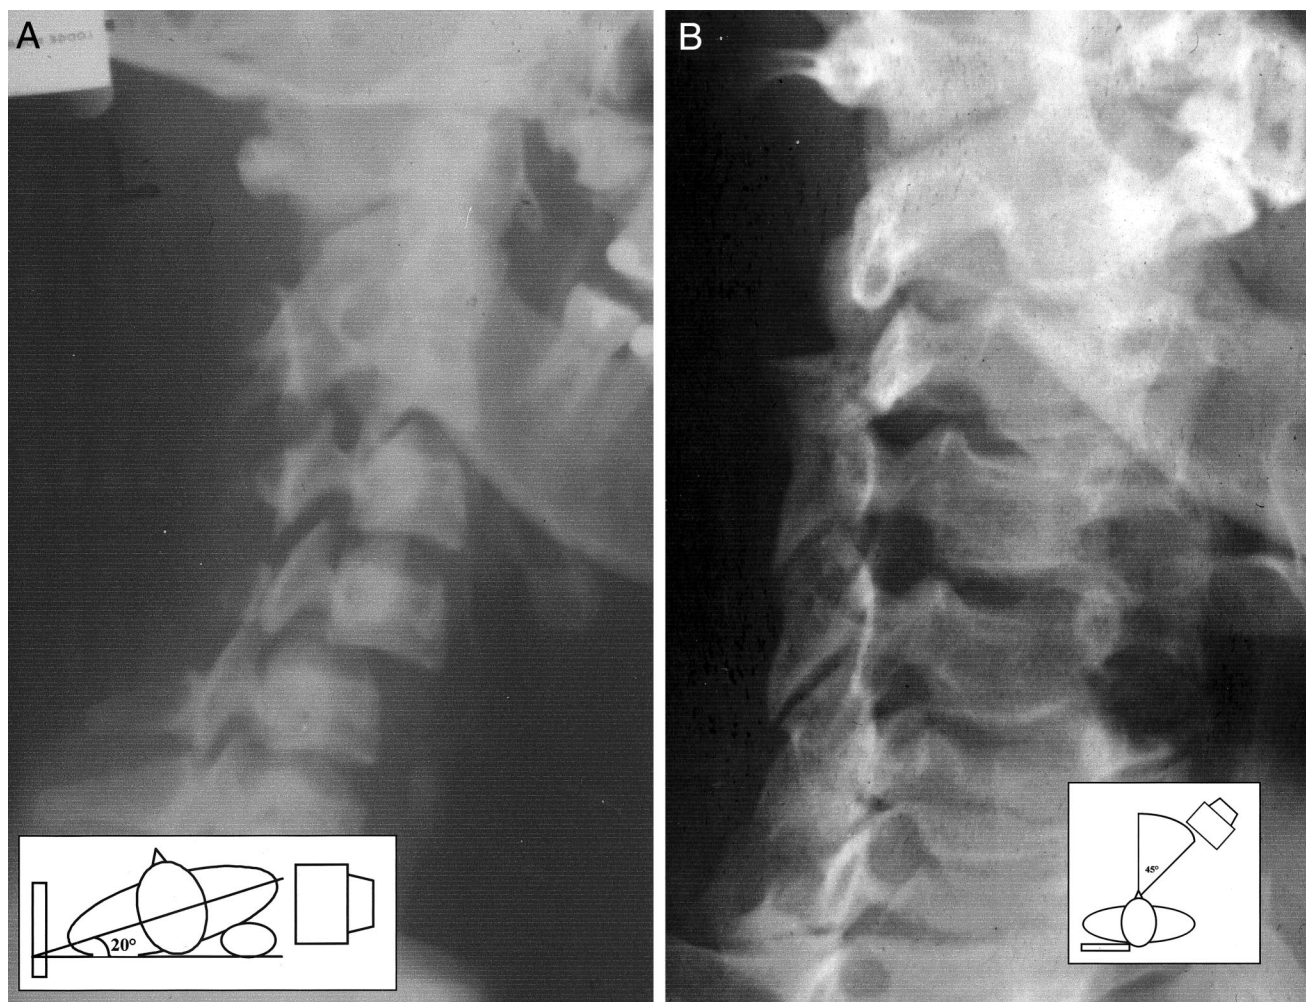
(A) Lodge Moor oblique view showing dislocation of C5/6 facet. These radiographs were obtained by inserting a pillow under one or the other shoulder. The facet seen in these radiographs correspond to the shoulder that is not elevated (see inset). (B) Oswestry oblique view showing dislocation of the C3/4 facet joint. These radiographs were obtained by sliding a radiograph cassette under the contralateral shoulder and neck while the x-ray beam was aimed at 45 degrees from the sagittal plane, centered at the anterior margin of the middle of the sternomastoid muscle (see inset).
